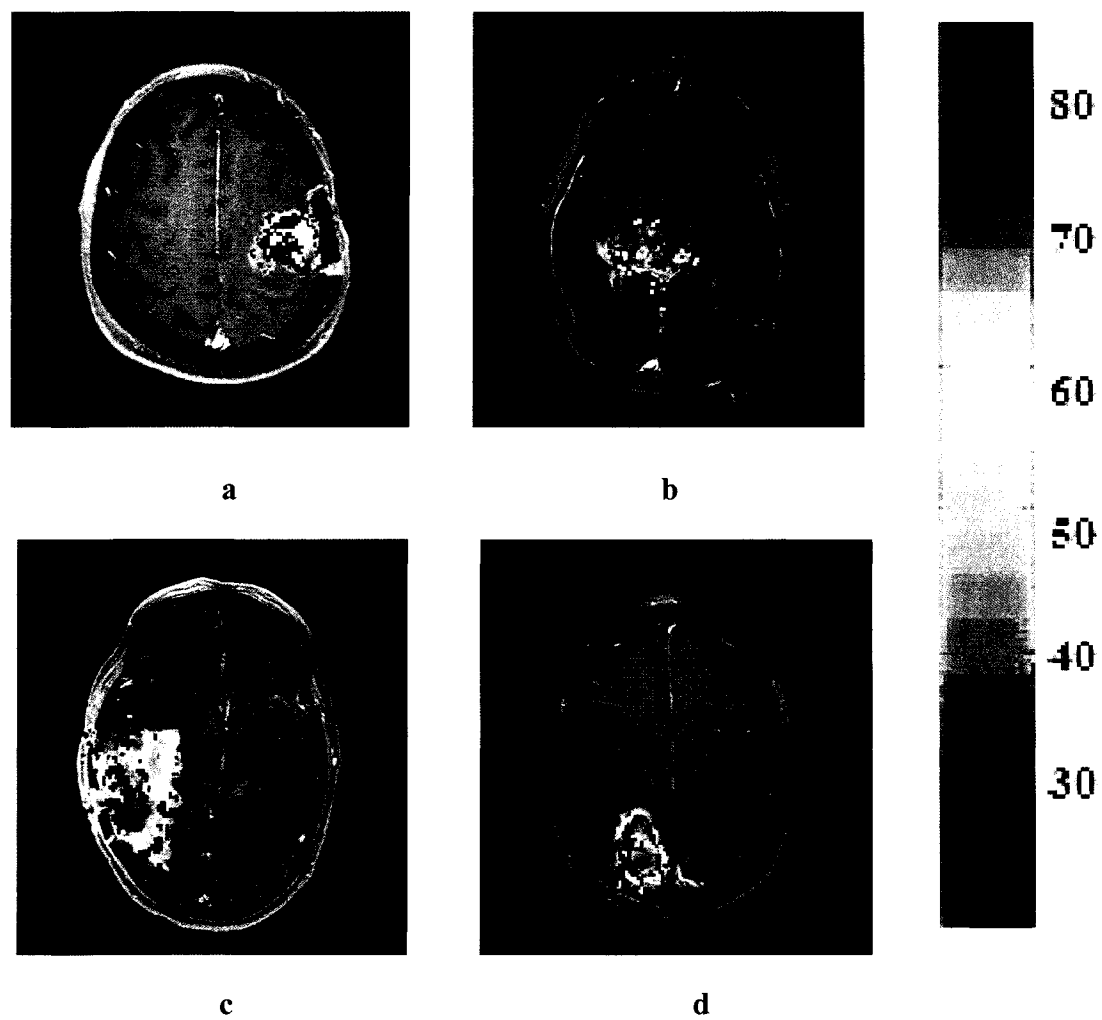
Angiogenesis potential maps of patients. Patients (a:2, b:3, c:4, d:5) overlaid onto respective post-contrast T1-weighted images. The tumor centroid in each case is represented by a red asterisk, in the center of the enhancing area.
